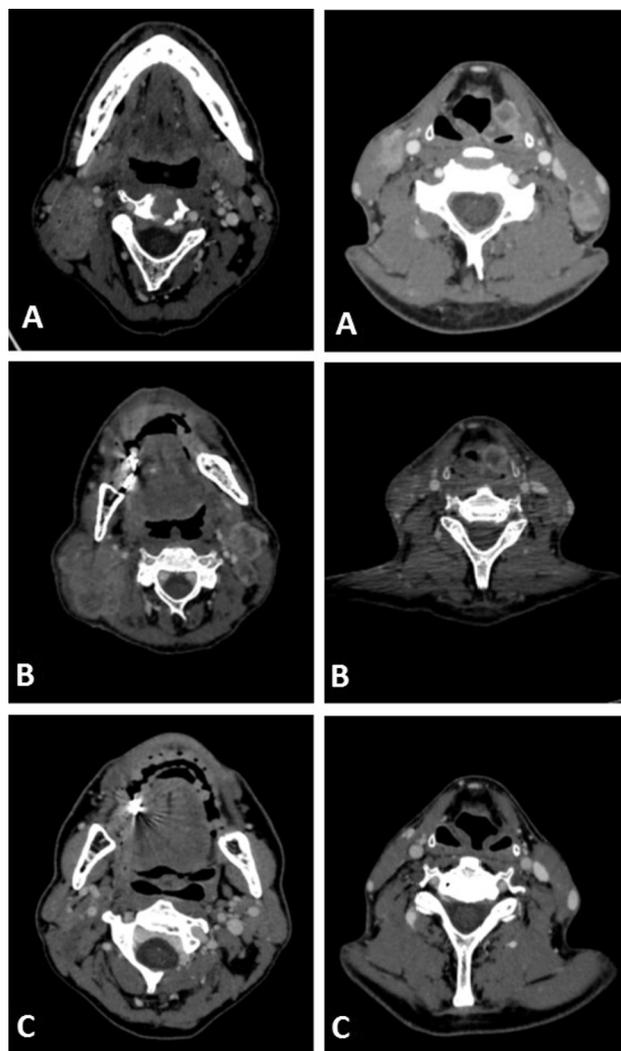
Computed tomography scan of the progression of the disease after treatment with afatinib (A), after three treatments with nivolumab (B), and after six cycles of salvage chemotherapy (C).
